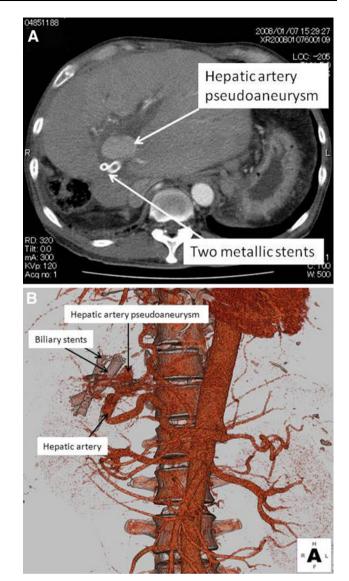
a Intrahepatic artery pseudoaneurysm seen in a contrastenhanced computed tomography scan. The hepatic artery pseudoaneurysm was located near the two metallic stents in the graft liver. b Three-dimensional reconstructed CT images demonstrated the intrahepatic pseudoaneurysm in the hepatic artery. Two biliary stents were also noted close to the intrahepatic pseudoaneurysm
